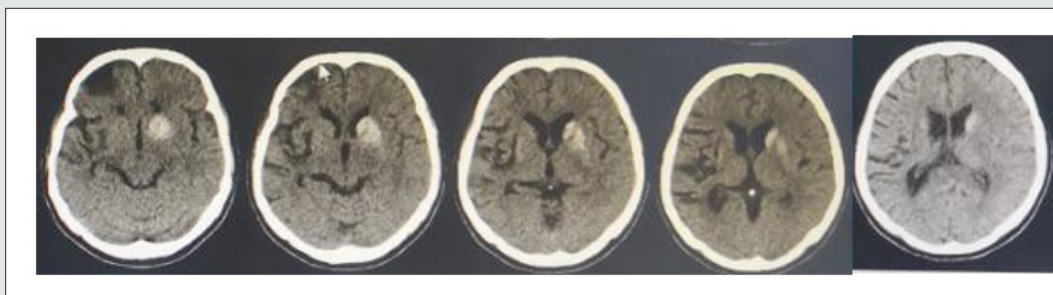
Cranial CT scan on Axial View.
